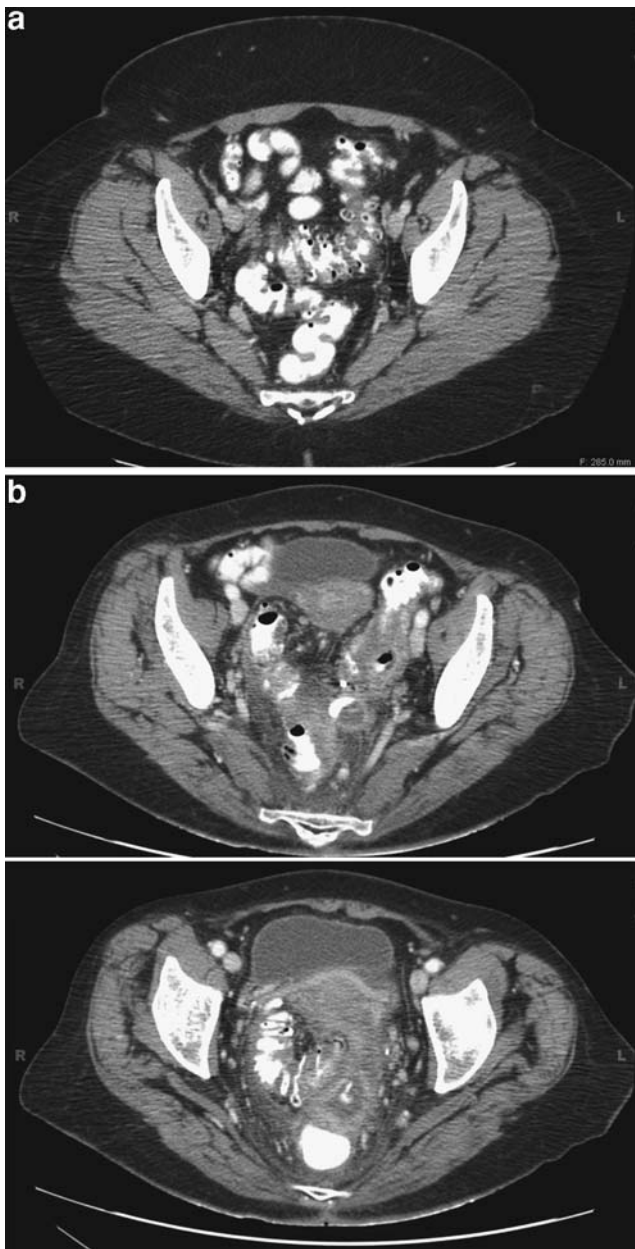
a Computed tomography scan images of a patient who presented with uncomplicated diverticulitis that was subsequently treated successfully with antibiotics. Note the thickening of the sigmoid colon, yet the lack of any extraluminal fluid or air. b Computed tomography scan images of a patient who presented with complicated diverticulitis and an extraluminal fluid collection that did not resolve with attempted CT-guided drainage and required an eventual sigmoid colectomy.
